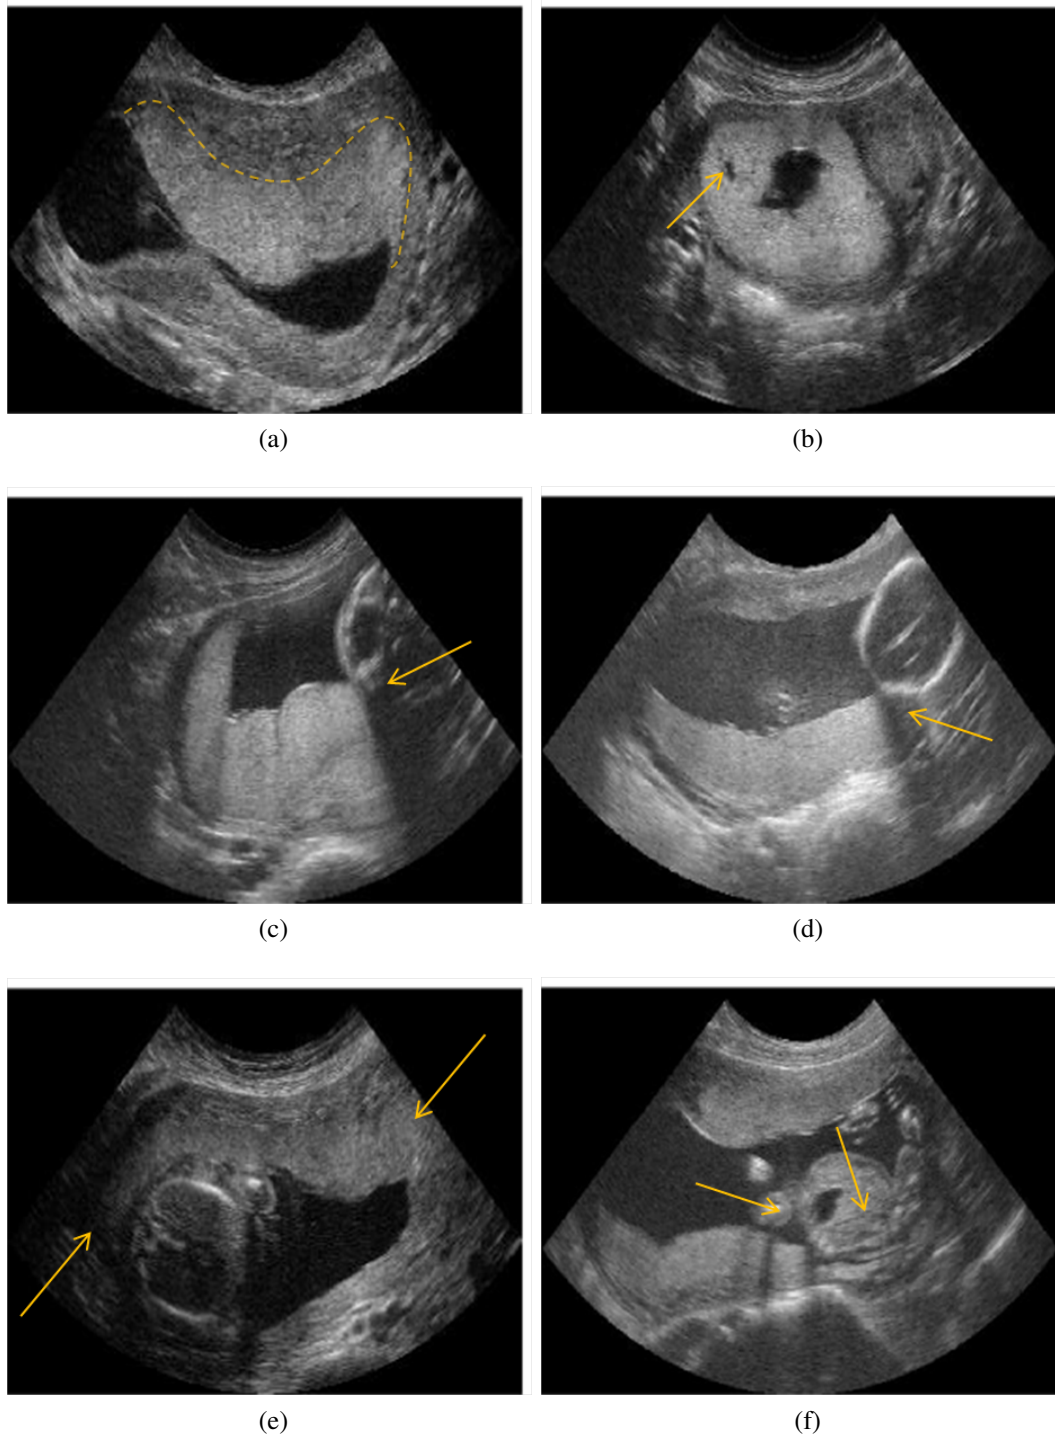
Slices of 3D volumes acquired to highlight challenges of identifying the placenta in 3D ultrasound scan. Figures show different issues to overcome : Figure 3.2a – identification of different uterine tissue layers. Figure 3.2b – utero-placental lakes. Figures 3.2c and 3.2d – shadowing. Figure 3.2e – outer borders attenuated. Figure 3.2f – fetal parts.
